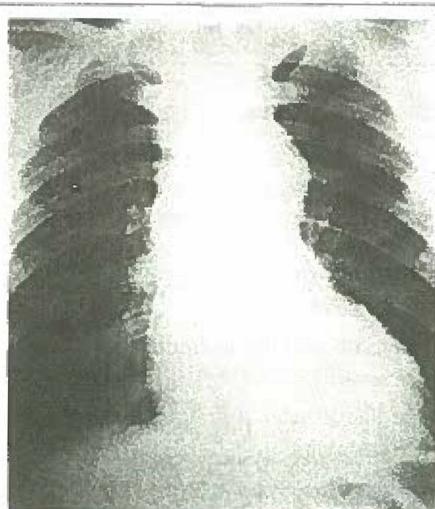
X-ray showing aortic stenosis
